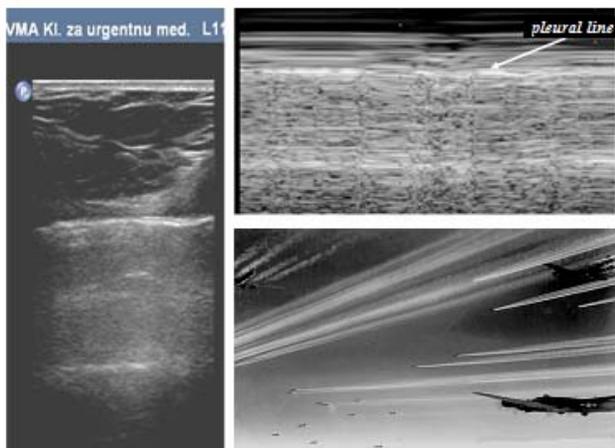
Pneumothorax diagnosed by ultrasound the two-dimensional image on the left shows A-lines, with no lung sliding or B-lines. On the right, the M-mode shows the “stratosphere sign” or the “barcode sign” – horizontal lines under the pleura, as a result of the presence of air in the pleural space.
